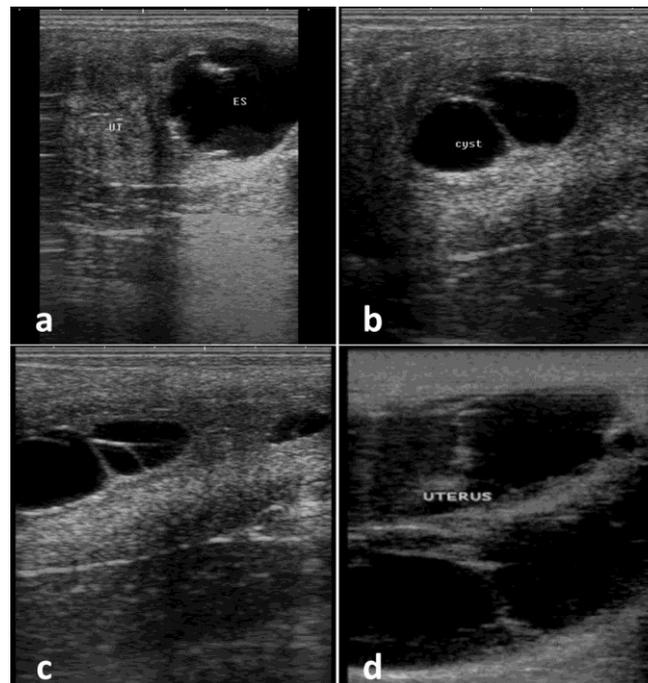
(a) Ultrasonography of endometrial cyst showing a large single anechoic cyst in the body of the uterus (close to the cervix) in a 12-year-old Straight Egyptian Arabian mare. (b) Double anechoic endometrial cysts in the body of the uterus of an 18-year-old Straight Egyptian Arabian mare. (c) Triple anechoic endometrial cysts occupying the whole body of the uterus until the base of uterine horns in a 14-year-old Straight Egyptian Arabian mare. (d) Multiple large anechoic endometrial cysts occupying the whole body of the uterus in two parallel rows extending from internal cervical os till the base of uterine horns in a 20-year-old Straight Egyptian Arabian mare.
